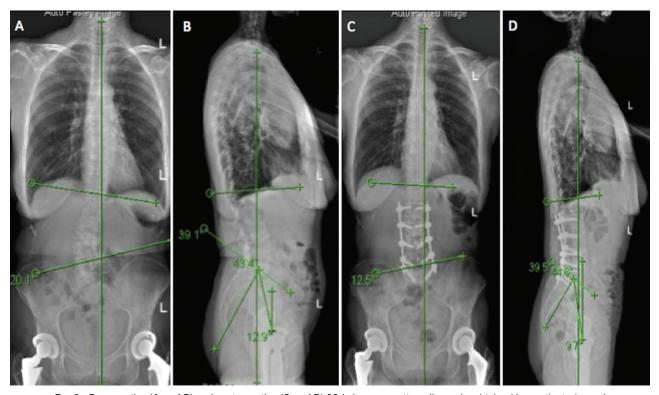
Preoperative (A and B) and postoperative (C and D) 36-in long-cassette radiographs obtained in a patient who underwent a minimally invasive correction of ASD. The radiographic parameters of LL, PI, SVA, and TK were measured.
